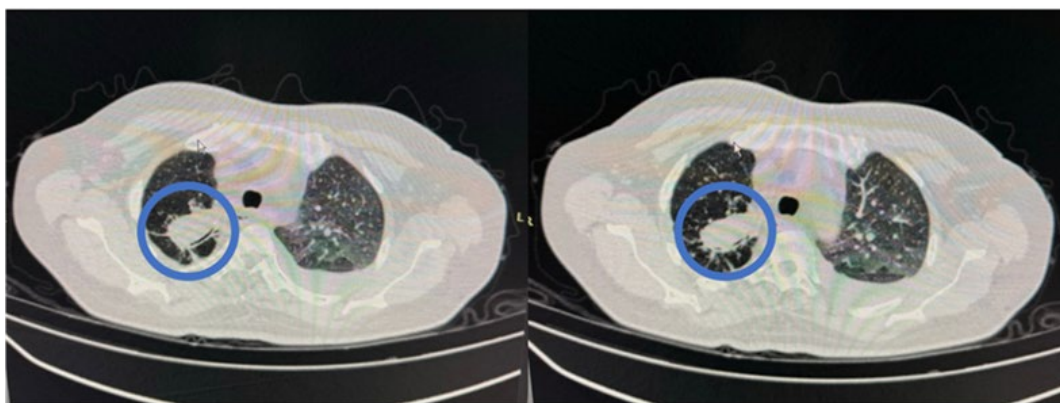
Repeat Chest CT showed a 19mm cavity in the right upper lobe
